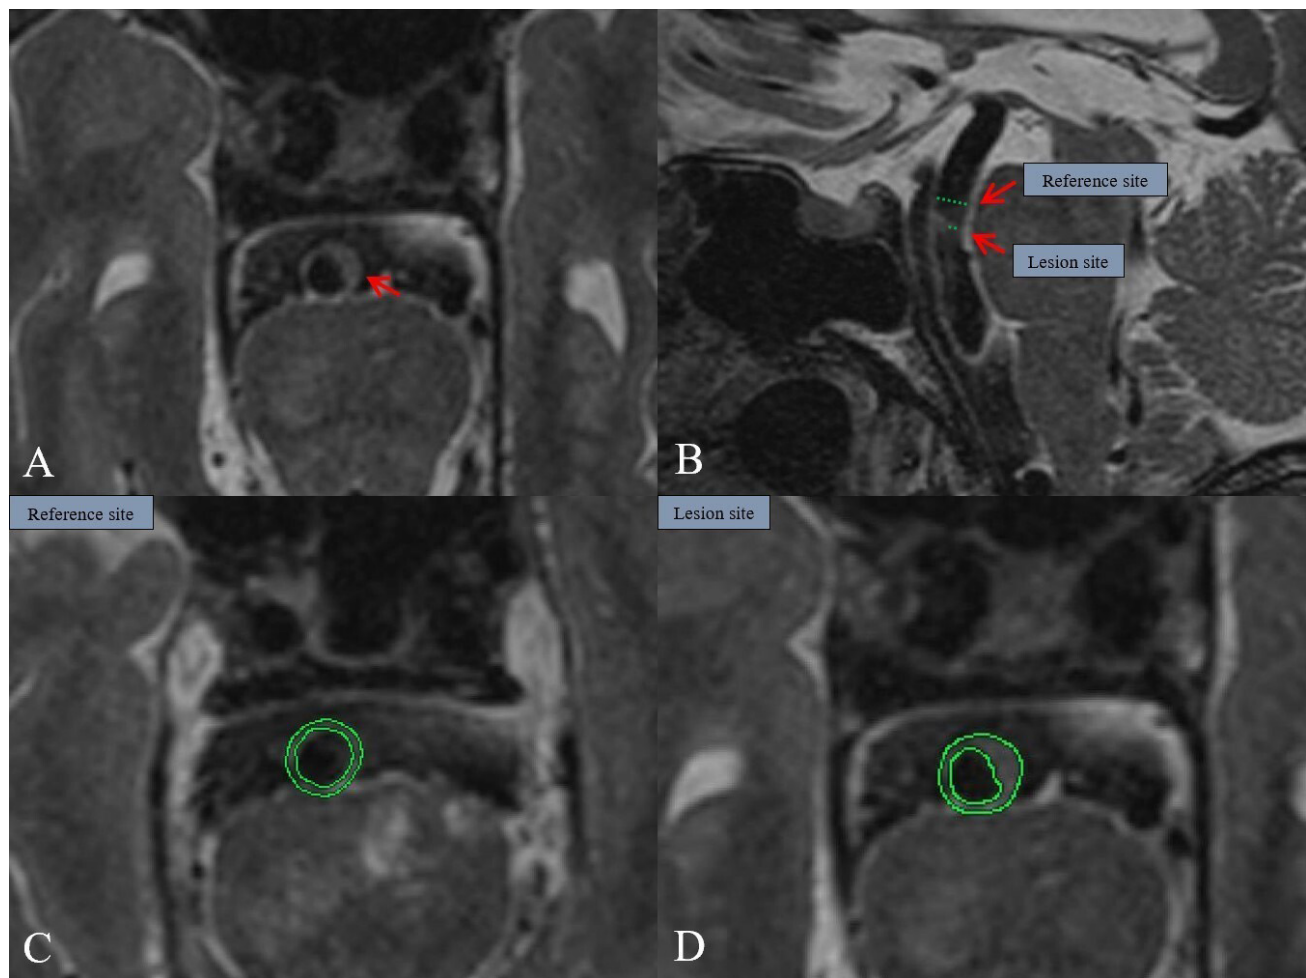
Magnetic resonance images of the vessel wall of a basilar artery plaque. Multiplanar reconstruction of the basilar artery was conducted using dedicated software. The morphology of the intracranial plaque at the site of maximum luminal stenosis (MLN) was thoroughly analyzed, and quantitative indices were measured (A). (B) (Red arrow) The reference site was selected as the nearest plaque-free segment that was either proximal or distal to the MLN site (C). (D) The thickest cross-section of the plaque was determined as the lesion site. For each of the measurements, including maximum vessel wall thickness, total vascular area, and lumen area, the process was repeated three times, and the average value was recorded for accuracy and consistency.
